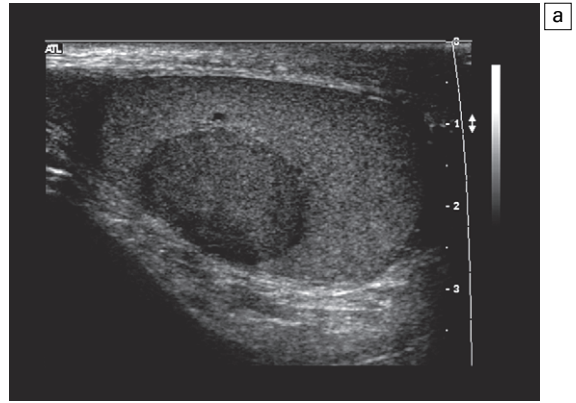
(a) Right scrotal sonography shows a well-defined solid mass without calcification in the right testis. (b) Colour Doppler shows the hypervascularity of the right testicular mass. Case courtesy of Kyoung-Sik Cho, MD, Asan Medical Center, University of Ulsan, College of Medicine.
